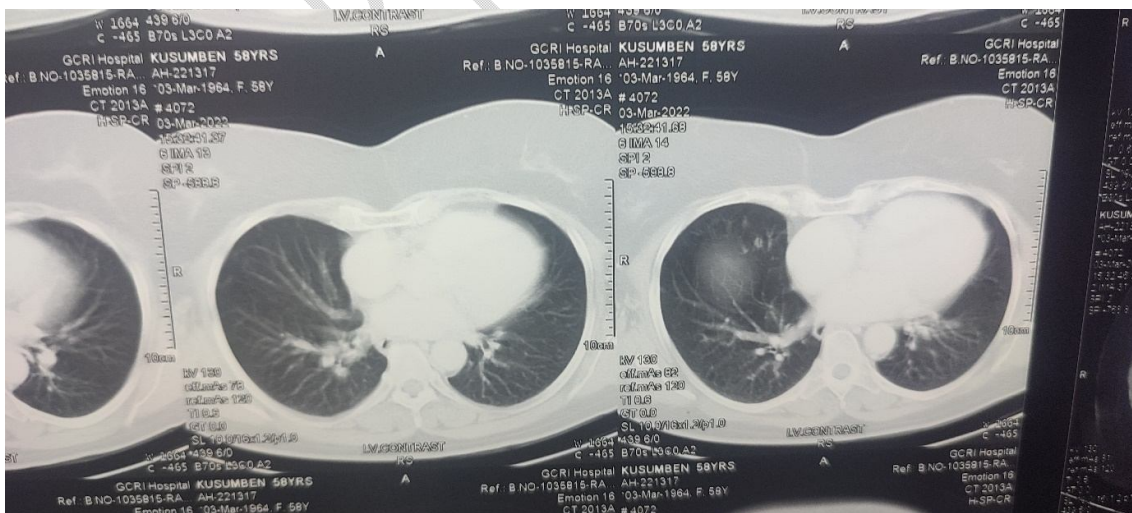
CT Chest post 9 weeks of MTX withdrawal showing resolution of primary lesion
